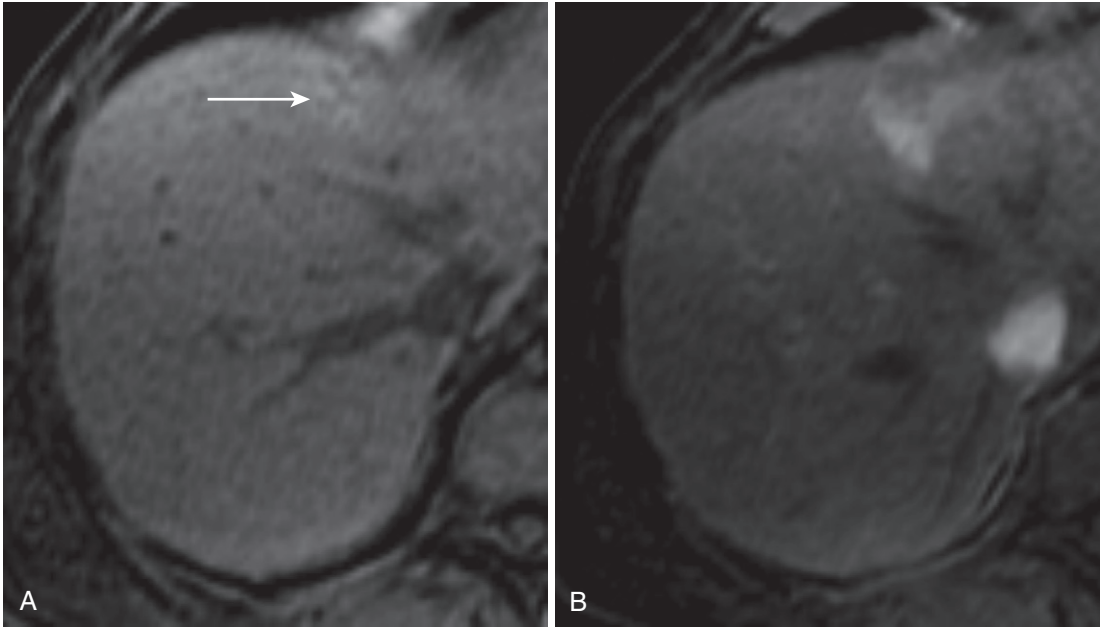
Intrahepatic cholestasis. A and B, Note the central tubular hypointensities within the peripheral triangular hyperintensity (*arrow* in A) in the T1-weighted fat-suppressed image in the medial segment correspond to dilated biliary radicles.
